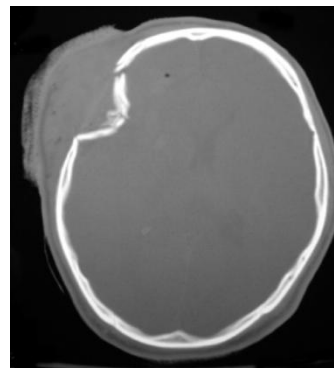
CT with bone window - depressed skull fracture
